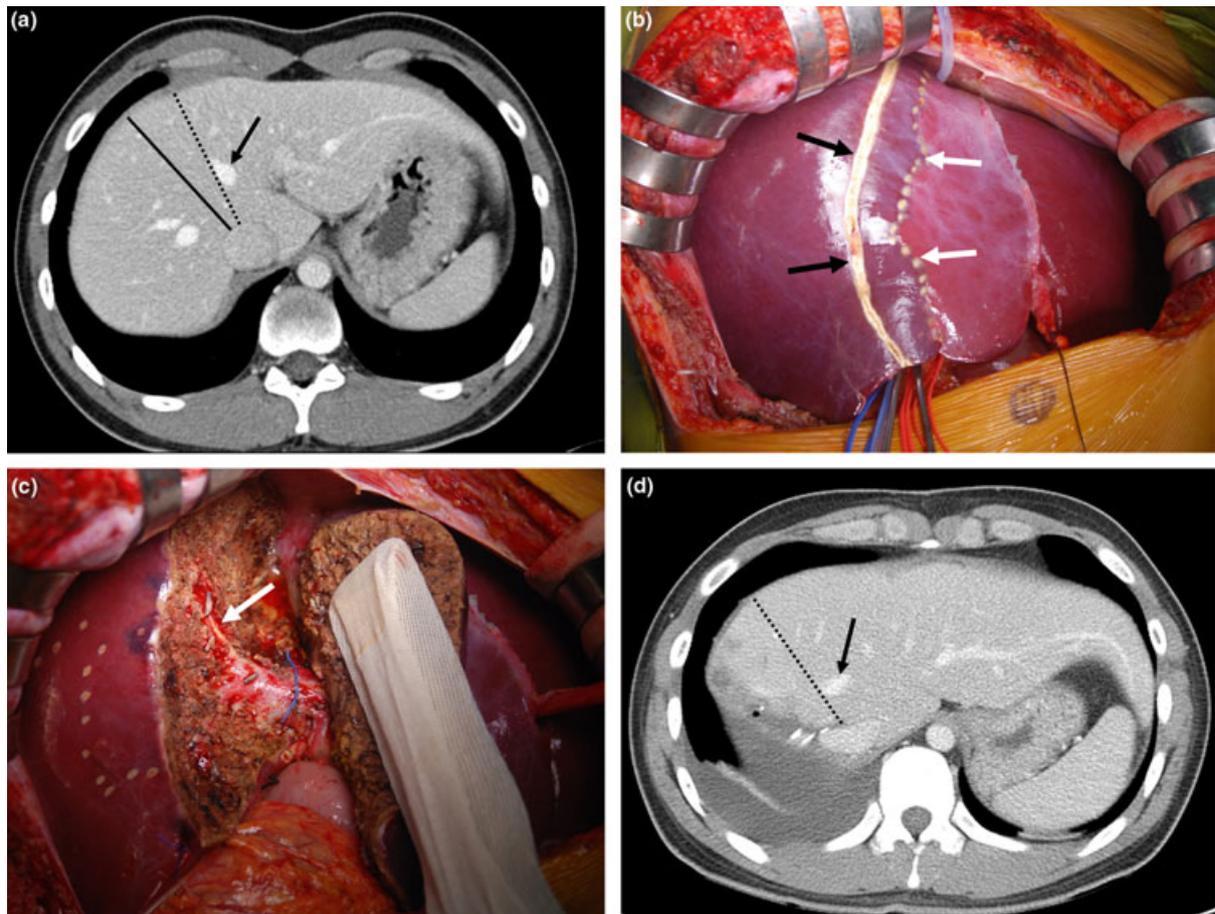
Right hepatectomy for procurement of a mRL graft. (a) The bold line indicates the hepatectomy plane for the mRL graft and the dotted line is the plane of the main portal fissure (MPF). Arrow indicates the middle hepatic vein (MHV). (b) The black arrows indicate hepatic transection line for an mRL graft, and the white arrows for inter-lobar demarcation line. (c) The right anterior portal pedicle was exposed (arrow) after parenchymal transection. (d) Posthepatectomy day 7 CT scan shows the MHV (arrow) is deeply located from the transection plane. The dotted line indicates the transection plane of conventional right hepatectomy.
